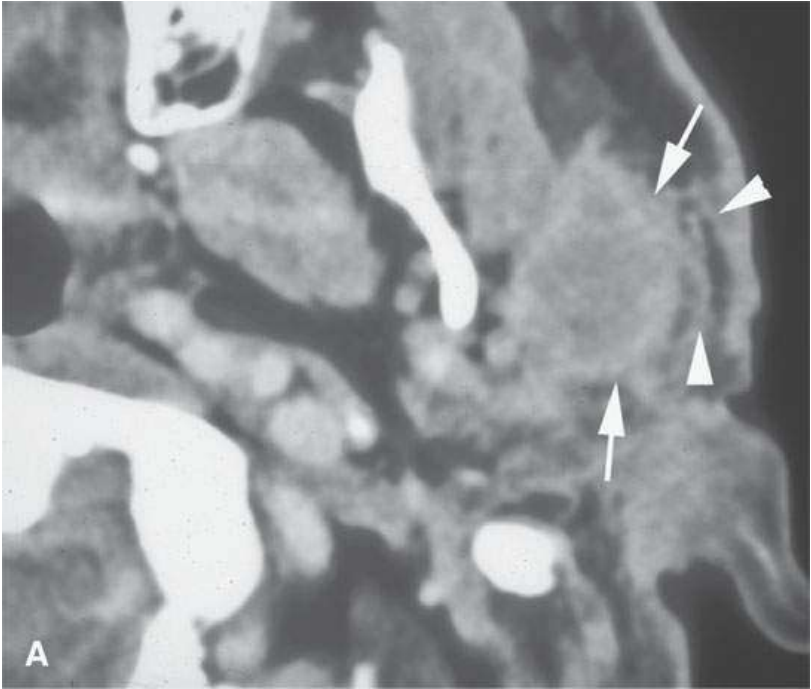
Computed tomography studies of adenocarcinomas arising in minor salivary glands. A, B: Contrast-enhanced computed tomography of a relatively indolent-appearing hard palate cancer (arrows) with relatively smoothly margined bone erosion. C: Tumor of the middle ear with no features that identify it as different from a cholesteatoma or other benign middle ear disease.
